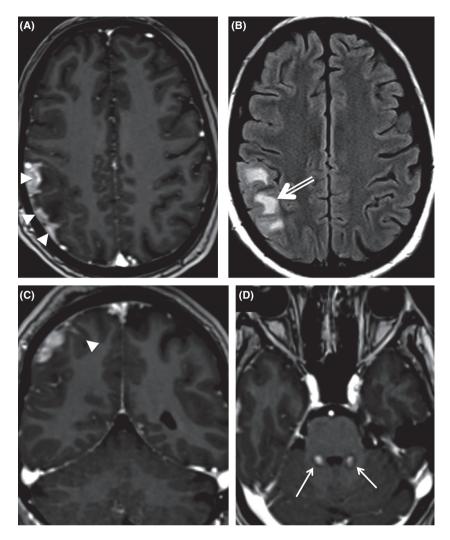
Axial view of a 3D T1-weighted MRI with gadolinium (A) and FLAIR (B) shows an enhanced dural thickening (arrowheads) with a parenchymal edema of the underlying cortex and subcortical white matter (double arrow). Coronal view (C) also reveals an involvement of the subarachnoid space (arrowhead). An axial view of the brain stem shows bilateral parenchymal enhancement of the cerebellar peduncles (arrows).
